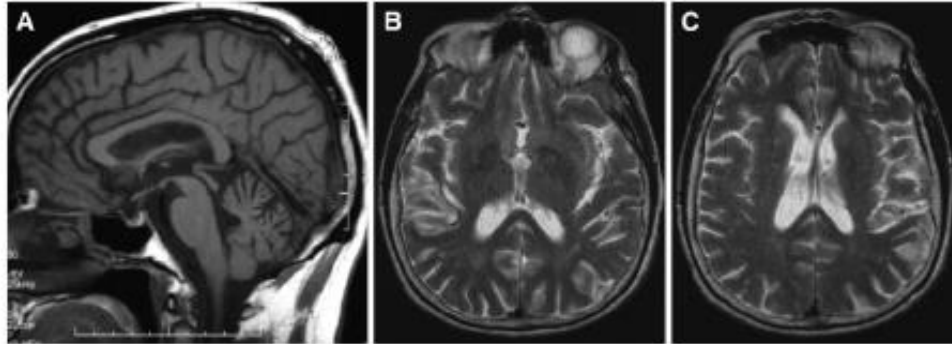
MRI findings in P102L IPD. (A) Sagittal T₁-weighted image (of 2.VII.2) showing cerebellar atrophy. (B) and (C) Axial T₂-weighted images (of VI.2) showing multiple white matter lesions in the basal ganglia. Similar findings were found in two other patients leading in one to a diagnosis of Binswanger's disease being made in combination with the clinical picture. These findings are probably incidental but the possibility of a link to P102L IPD remains. TEF Webb, 2008
